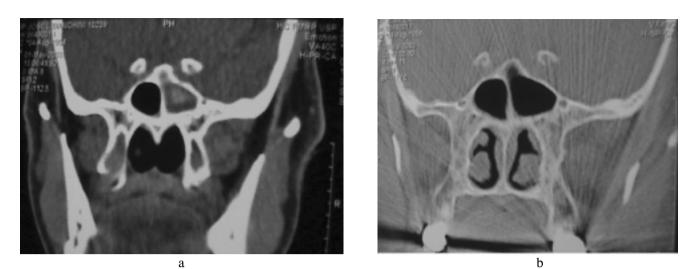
Fungal rhinosinusitis in patient 3: (a) preoperative and (b) postoperative CT scans.
